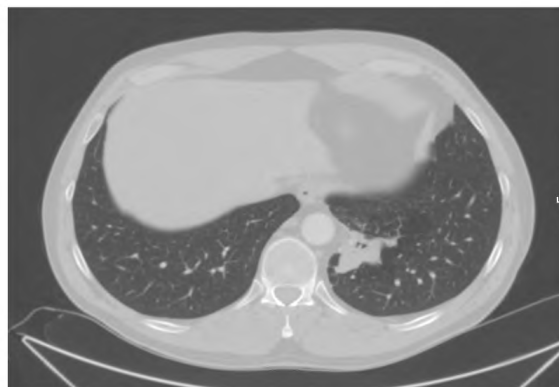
Axial CT image shows nodular lesions and accompanying dilated bronchi with air-fluid levels at the mediobasal segment of the left lobe.
